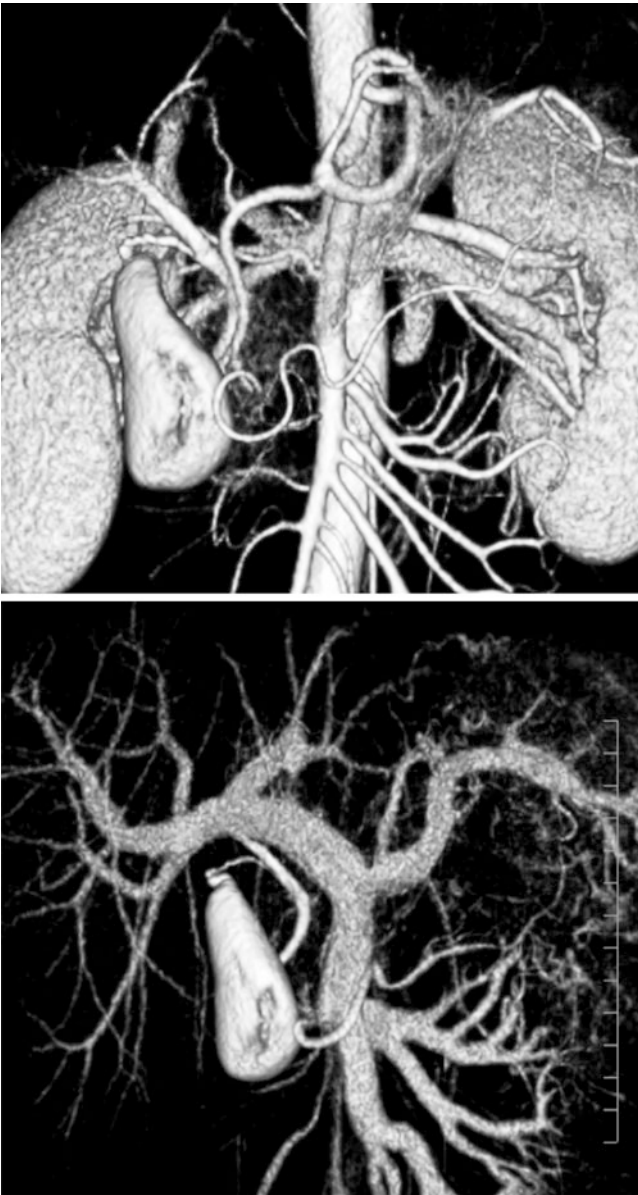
Imaging of 3D CT
